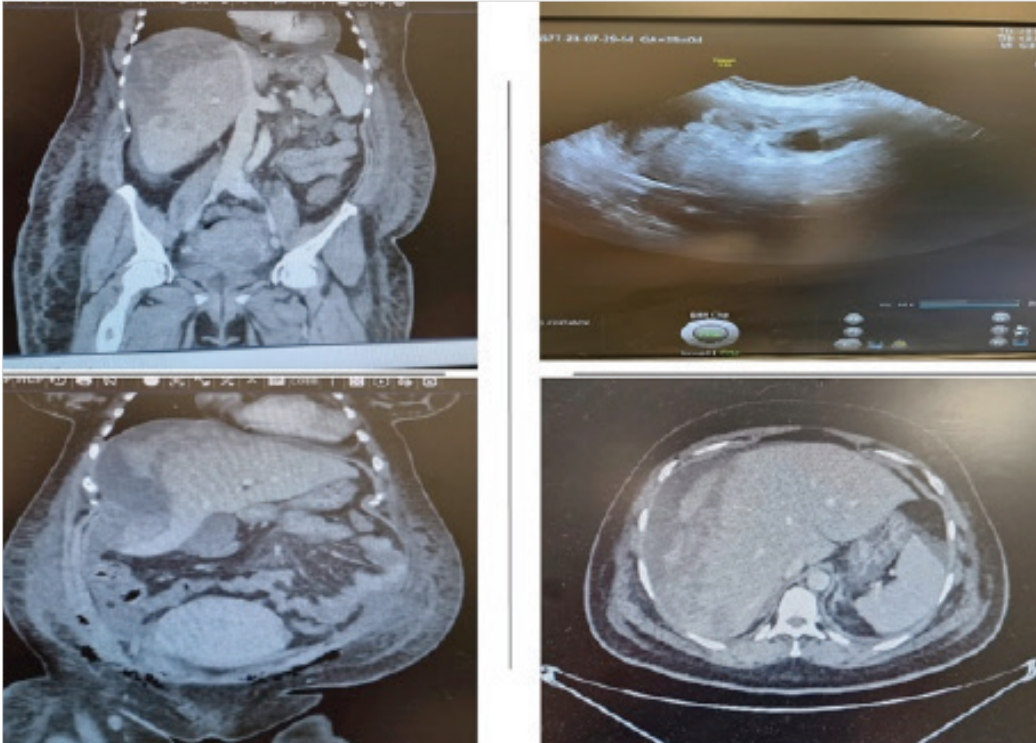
Preoperative radiologic appearance. Preoperative ultrasonography and tomography images show diffuse hematoma areas starting at the level of liver segment 7-8 with subcapsular spread.
